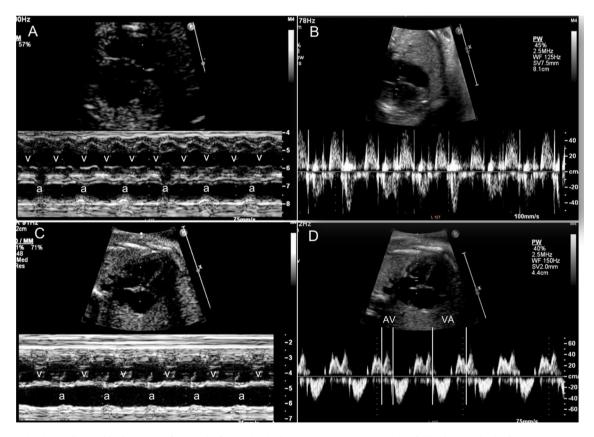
Fetal echocardiographic images before and after arrhythmia management. a M-mode of ventricle and atria showing regular ventricular contractions (v) at the rate of 213/min in the upper panel and regular atrial contractions (a) at the rate of 131/min in the lower panel. The ventricular rate is higher than the atrial rate with atrioventricular dissociation. b Doppler interrogation during tachyarrhythmia showing bizarre inflow–outflow relationship with no definite
